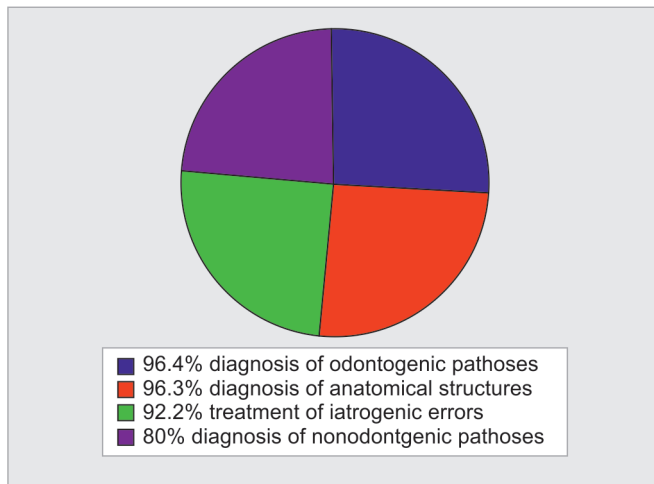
CBCT and diagnosis
